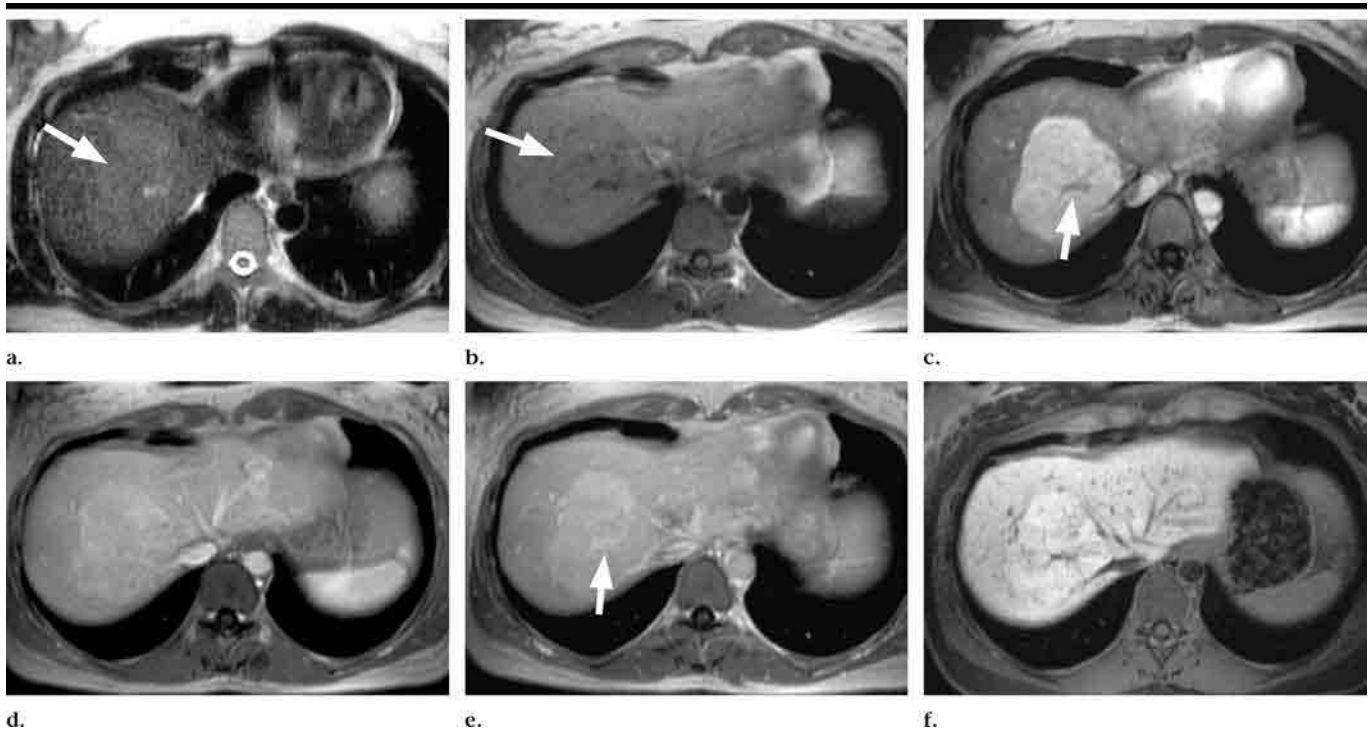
MR images in a 38-year-old woman with typical FNH, pain in upper abdomen, and 10-year history of oral contraceptive use. (a) Transverse T2-weighted half-Fourier RARE ($\infty/74$, 180° flip angle) image shows a faintly hyperintense lesion (arrow) of approximately 8 cm in liver segment VIII. (b) On unenhanced transverse T1-weighted GRE ($140/4.7$, 70° flip angle) image, the lesion (arrow) is very faintly hypointense to the surrounding parenchyma. (c) On corresponding postcontrast arterial phase T1-weighted GRE image, the lesion demonstrates strong homogeneous enhancement and retains a faint hyperintensity during subsequent (d) portal venous and (e) equilibrium phases. A characteristic central scar (arrow in c and e) is clearly seen as hypointense in arterial phase and as hyperintense in equilibrium phase. (f) Although FNH diagnosis is likely based on dynamic phase images alone, confirmation comes from a marked hyperintense appearance of the lesion on hepatobiliary phase fat-suppressed T1-weighted GRE image acquired 3 hours after gadobenate dimeglumine injection. The central scar is again hypointense during delayed hepatobiliary phase.
